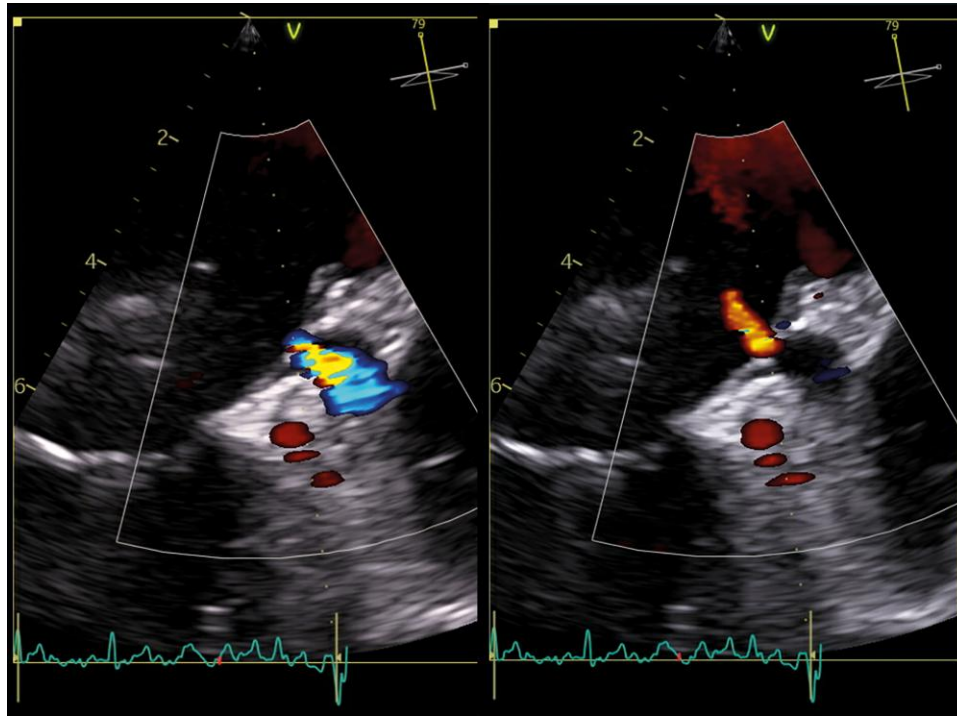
Transoesophageal echocardiographic image (midoesophageal, 79°) of a to (left) and fro (right) flow of blood across the membranous structure at the LAA orifice, end-systolic, respectively.
